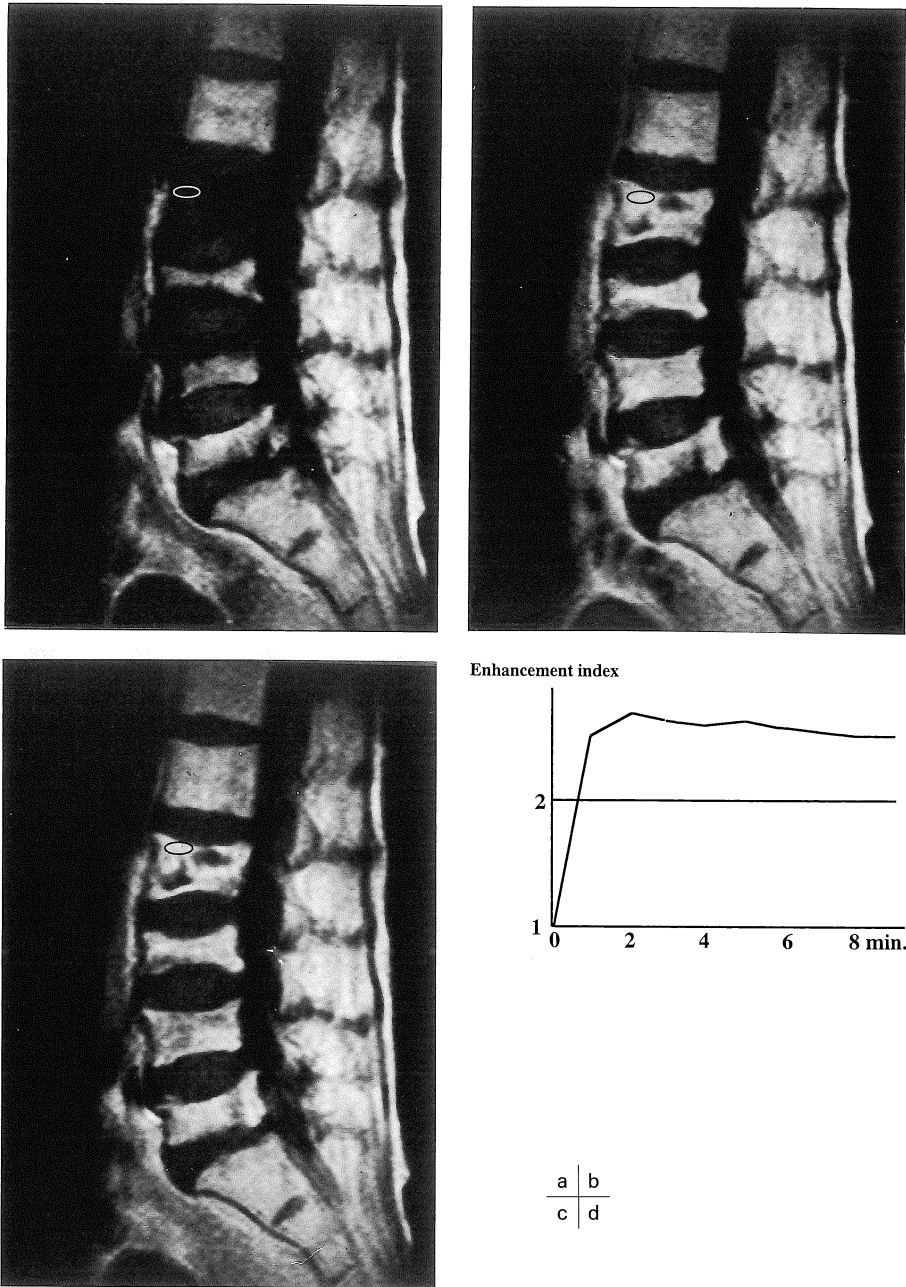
Dynamic MR images of osteoporotic compression fractures of vertebral bodies. An elliptically region of interest was plotted in compressed vertebral body.
